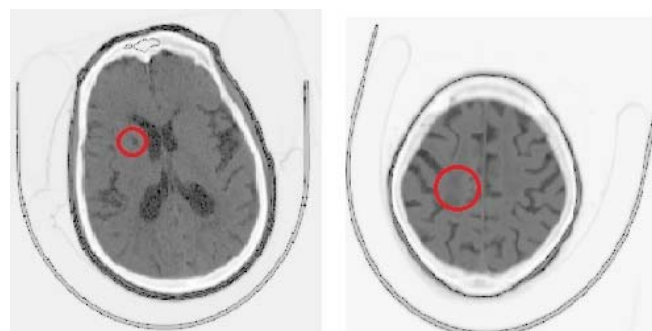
Hypo densities noted in the CT images after logarithmic enhancement
